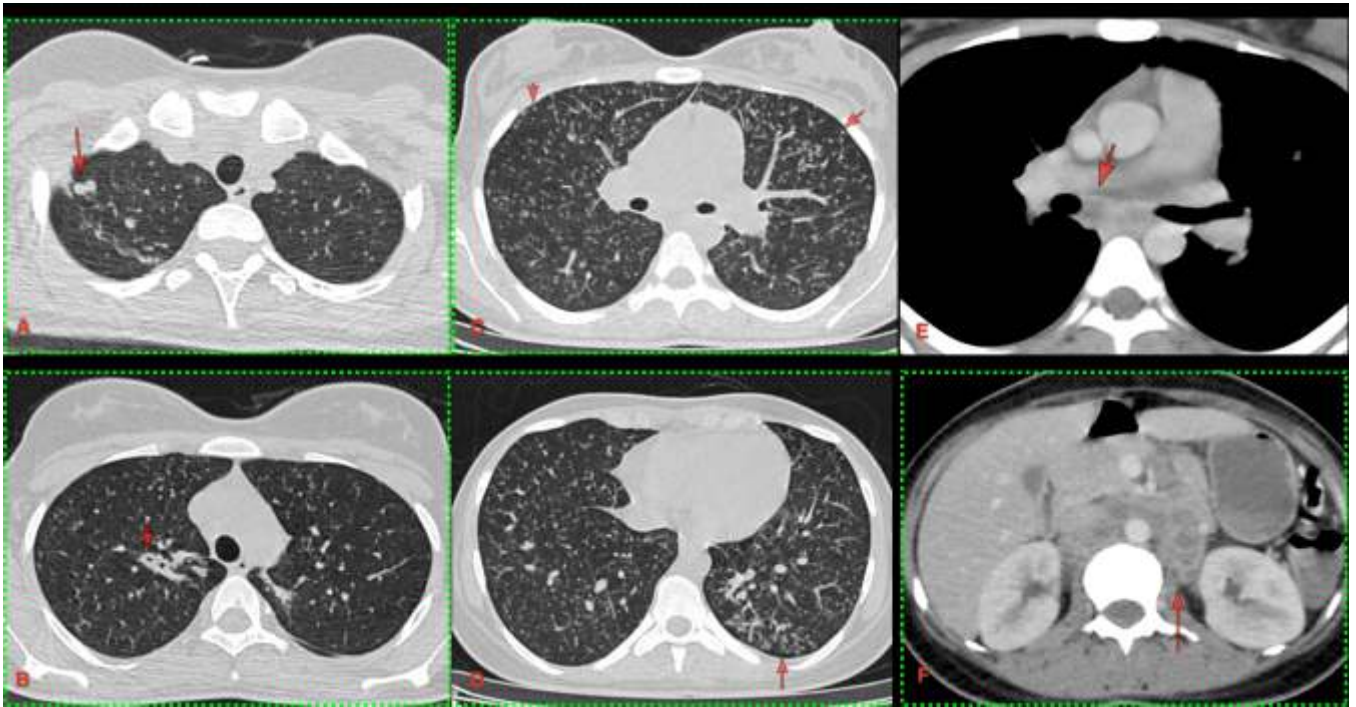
(A-F). Tuberculosis. Multiple different manifestations in this 21-years old. Axial CT (A) through the upper lobes shows evidence of old infection with a fibronodular lesion (arrow). The next image (B) also through the upper lobes, shows peribronchial thickening and tubular bronchiectasis (arrow), suggestive of airway involvement. The next image (C) in the infracarinal mid-zones shows classic miliary nodules (arrow), suggestive of hematogenous spread. The next image (D) through the lower lobes, shows classic “tree-in-bud” (arrow), suggesting airway or transbronchial spread or dissemination (infectious bronchiolitis). A delayed contrast study (E) shows a necrotic subcarinal node and the last contrast study (F) through the upper lobe, shows large, conglomerate retroperitoneal nodes. The patient also had miliary splenic nodules and hepatomegaly.
